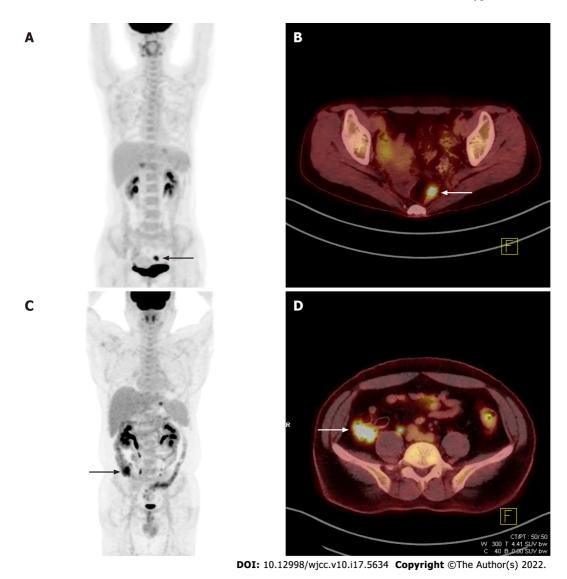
Cases with premalignant and benign incidental focal colorectal fluorine-18 fluorodeoxyglucose uptake. A: Focal uptake (black arrow) in the lower abdomen on the maximum intensity projection (MIP) image of a 41-year-old woman diagnosed with stomach cancer; B: Axial view showing a hypermetabolic rectal lesion (white arrow, SUVmax 10.1) diagnosed as rectal villous adenoma; C: Focal uptake (black arrow) in the right lower abdomen on the MIP image of a 42-year-old man diagnosed with stomach cancer; D: Axial view showing hypermetabolism (white arrow, maximum standardized uptake value 8.6) with a final colonoscopy report of "No remarkable mucosal lesion".
